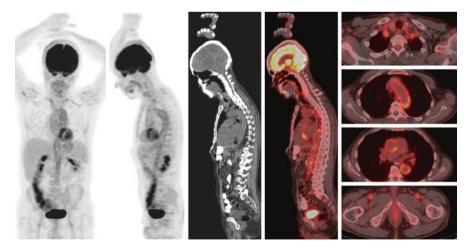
PET/CT Images of a patient showing increased 3 fluorine-18 fluorodeoxyglucose (FDG) uptake (higher than liver uptake) in biateral carotid, subclavian, axillary, iliac, femoral arteries and assending-arcus-abdominal aorta
